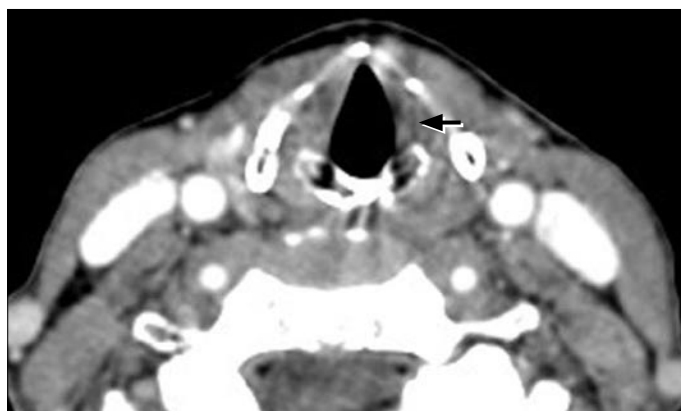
Axial CT image just inferior to the dilated laryngeal ventricle demonstrates the reduced size of the left thyroarytenoid muscle, or true vocal cord, with decreased density (arrow).
